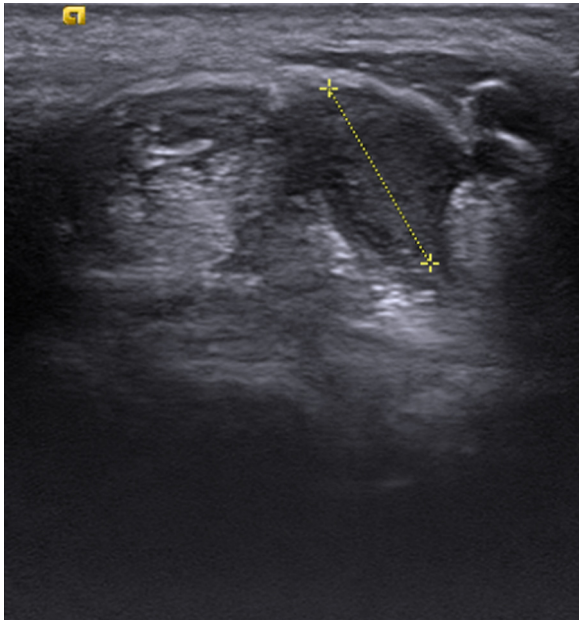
Axial ultrasound at level of distal radioulnar joint in clenched fist position.
